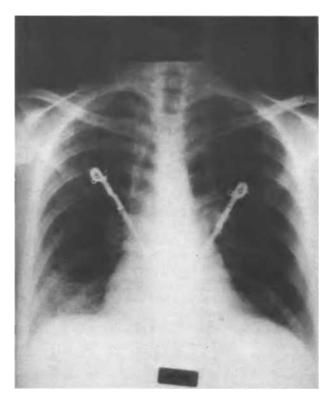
Chest radiograph of the same patient 6 h after initiating antirejection therapy, demonstrating marked clearing of the left lower zone opacification
